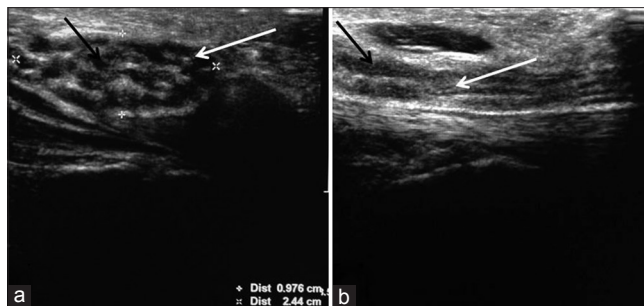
Transverse (a) and sagittal (b) high resolution sonography at the level of wrist showing enlarged median nerve with brighter hypertrophied abnormal intraneural soft tissue (white arrow). Note the compressed nerve fibrils showing relatively lower echogenicity within (black arrow)
